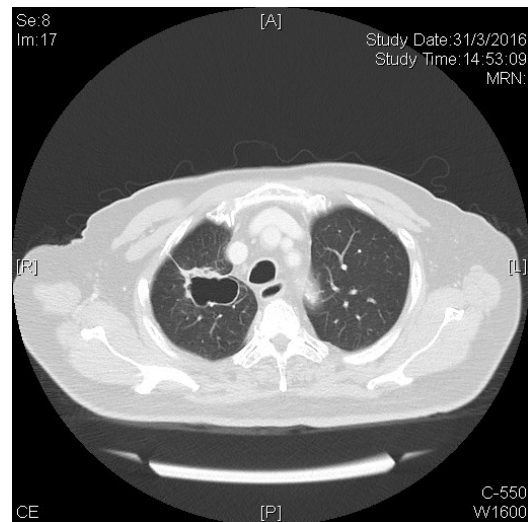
Follow up CT scan
